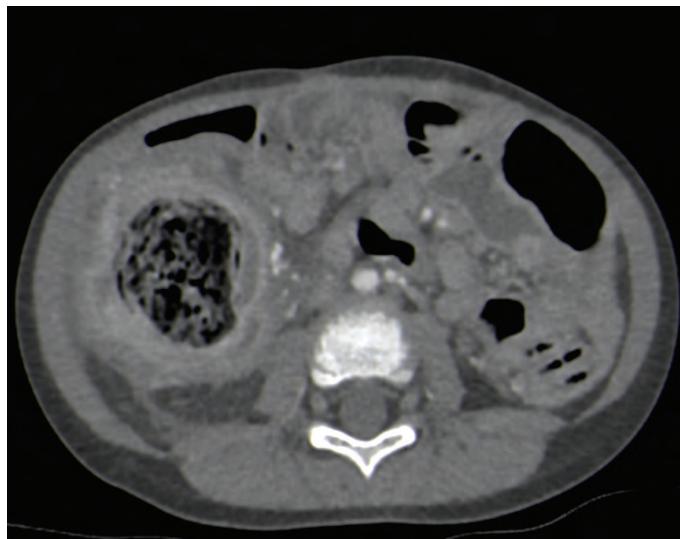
Abdominal computed tomography scan demonstrating a large hypodense formation with a hyperdense border at the right lateral canal, inflammatory changes in the adjacent structures
